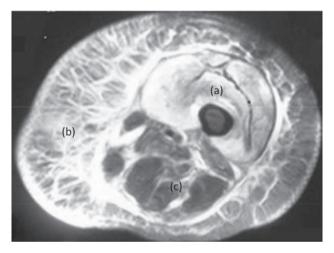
MRI scan of the transverse section of the left mid thigh and T2 fat saturation sequence. (a) shows muscle oedema and swelling, (b) shows subcutaneous oedema and (c) shows muscle atrophy. MRI = magnetic resonance imaging.
